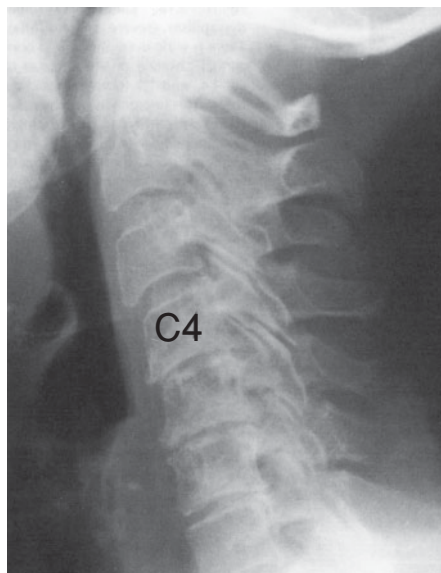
Lateral radiograph of a spondylolysis with spondylolisthesis.
